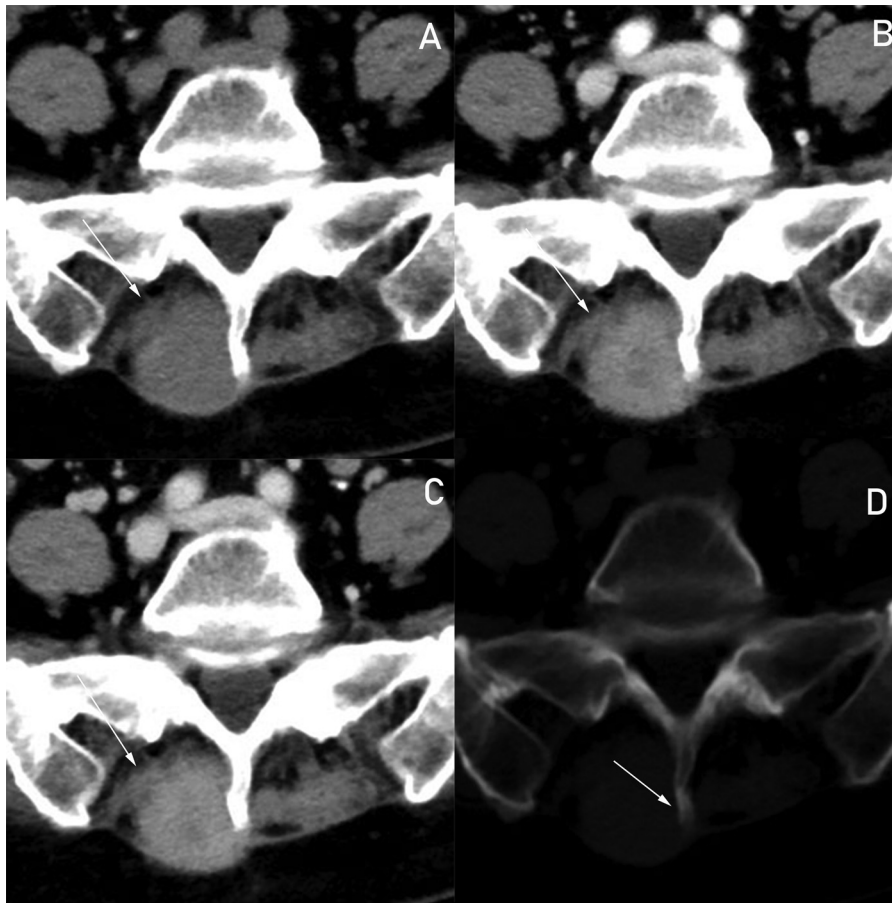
Axial CT demonstrating a homogeneous solid mass (arrow) in the right multifidus muscle (A), After the injection of contrast, the mass was shown the obvious heterogeneous enhancement, and the low-density area with mild enhancement was seen in the center of mass (B, C). There is no osseous involvement (D) .
